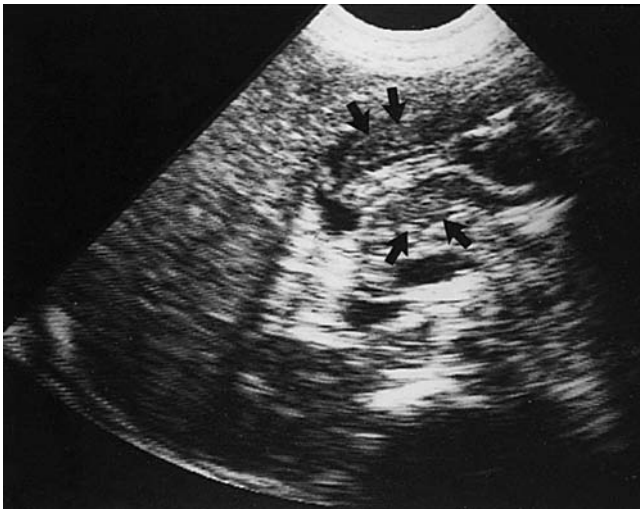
Hypertrophic pyloric stenosis. Ultrasonography of the abdomen shows thick pyloric muscle surrounding a centered echogenic mucosal and submucosal region (*arrows*).
